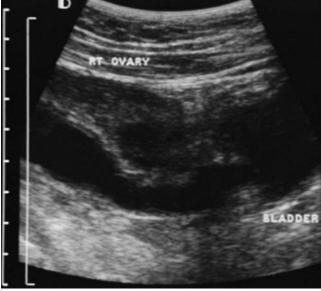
Sagittal sonogram of the right lower quadrant.
